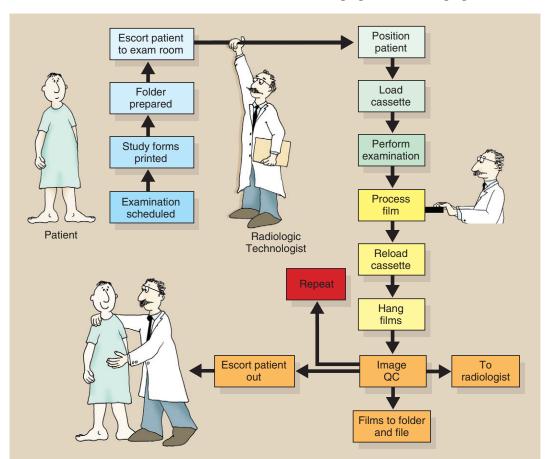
Sequence of activity for screen-film radiography.
